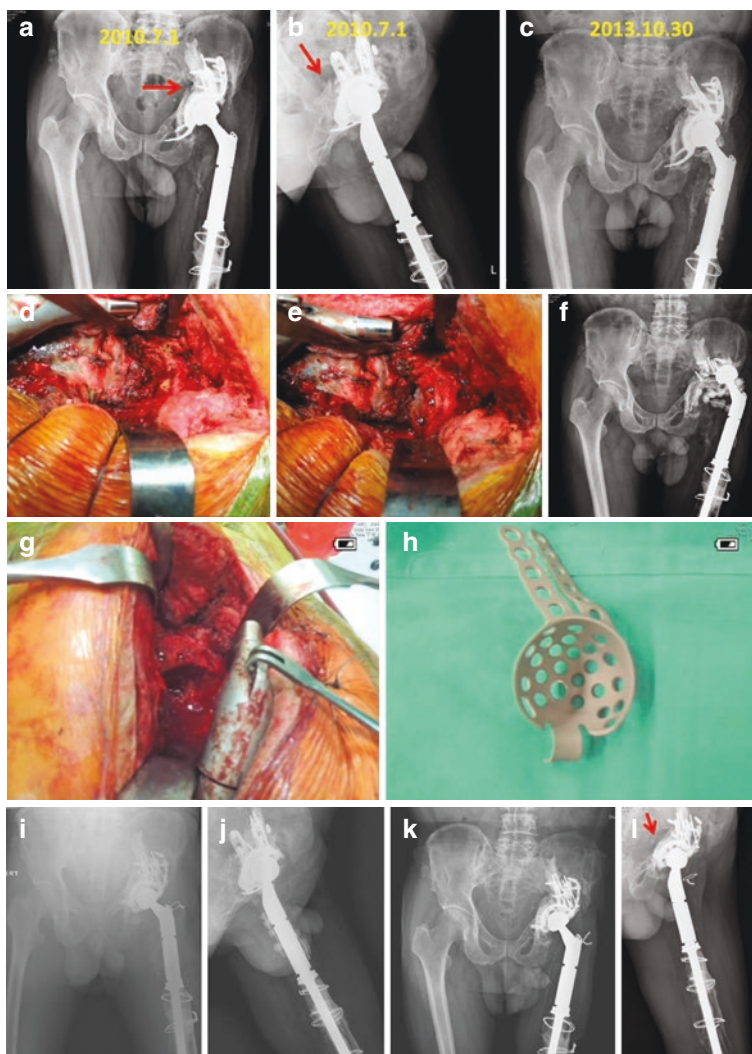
A 57-year-old man with failed cage reconstruction due to the nonunion of the acetabulum (pelvic discontinuity) for 5 years. Radiographs showing acetabular floor nonunion (arrows) and loose cage (a and b). Three years later, the patient complained of pain and crepitation of the left hip during hip motion. Radiograph showed migration of the cage (c). During surgery (2014-02-25), obvious nonunion of the acetabular superior wall was observed (d). The defect was repaired with a strut corticocancellous iliac autograft and fixed to the remaining acetabulum with three screws (e). Three months after autografting, healing of the acetabular defect was seen (f). A new anti-protrusion cage in conjunction with a bulk allograft fixed with screws was used for acetabular reconstruction on 2014-08-21 (g and h). Postoperative radiograph showed no visible gap in the acetabulum and optimum cage position (i and j). Two years later (2016-11-02), the radiograph showed solid healing of the pelvic discontinuity (arrows) and well-fixed cage and cup without radiolucent line. Patient was satisfied with the clinical outcome (k and l) (these pictures were agreed by the patient for publication)
